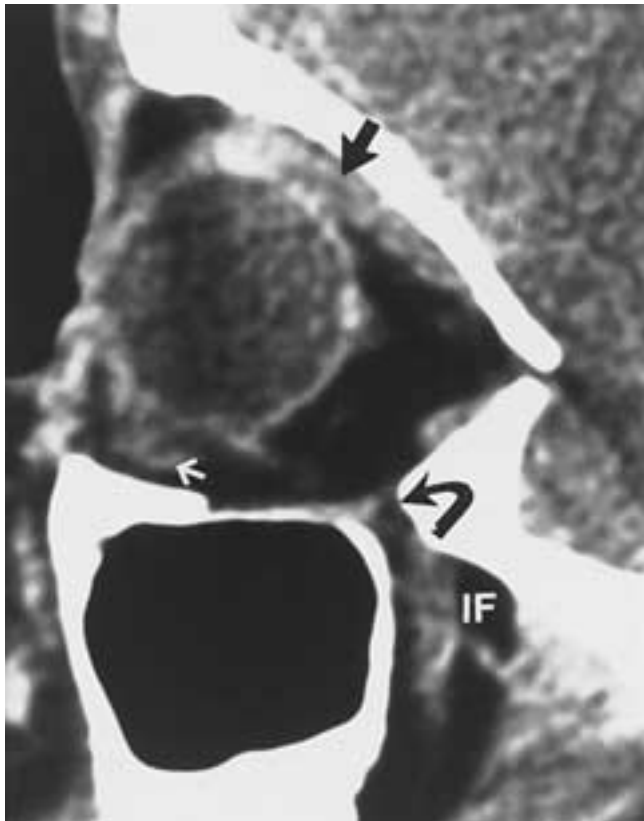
Direct parasagittal CT scan shows lateral extension of inferior orbital fissure (curved arrow) into infratemporal fossa (IF). Note inferior oblique muscle (white arrow) and superior rectus muscle (black arrow).
